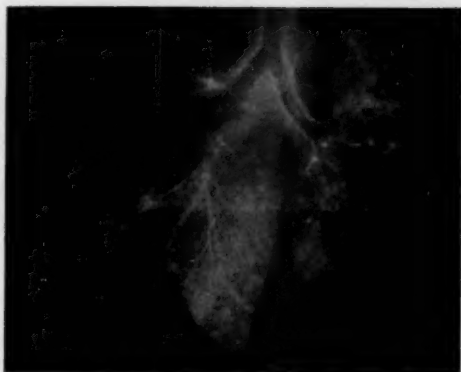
Radiograph at autopsy of the lungs of a patient into whose stomach barium had been introduced after death. Manipulations during removal of the lungs has squeezed barium into the alveoli
